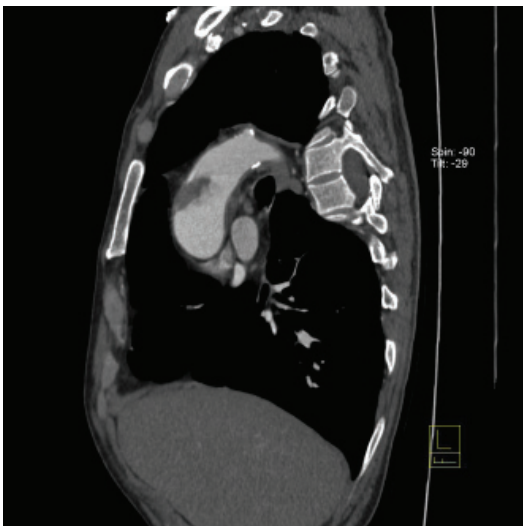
Ascending aortic thrombus, thoracic CT angiography sagittal section.
